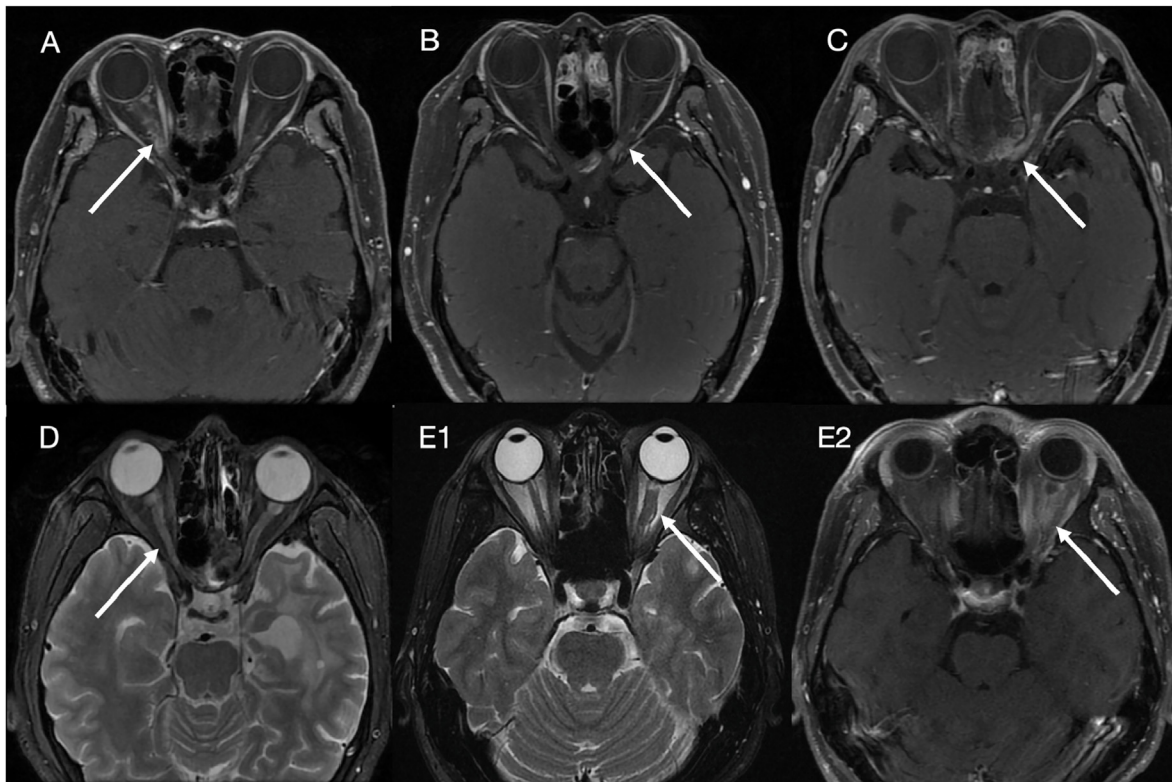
Lesions of RION on MRI examination. (A) Intraorbital segment (T1 Gado sequences); (B) Canalicular segment (T1 Gado sequences); (C) Intracranial segment (T1 Gado sequences); (D) T2-high signal; (E1&E2) Nerve enhancement with expansion (D = 75 mm) (T1 Gado sequences) & T2-high signal.
